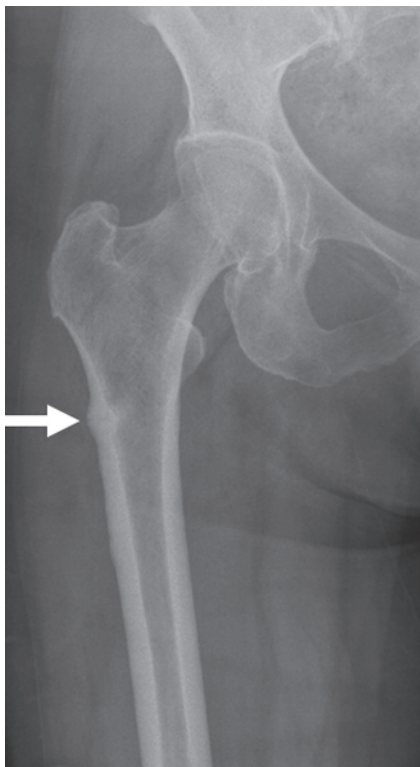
Insufficiency fracture in a patient on bisphosphonate therapy. AP radiograph shows focal lateral cortical thickening involving the lateral proximal femoral shaft (arrow).
